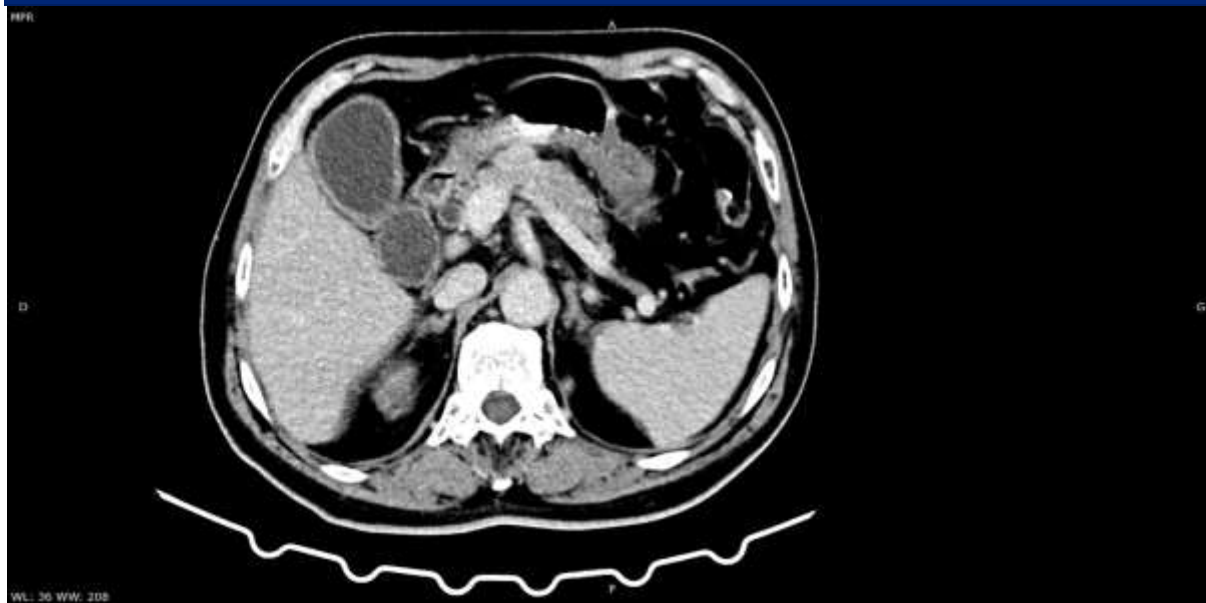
Abdominal CT scan showed stage A pancreatitis.
